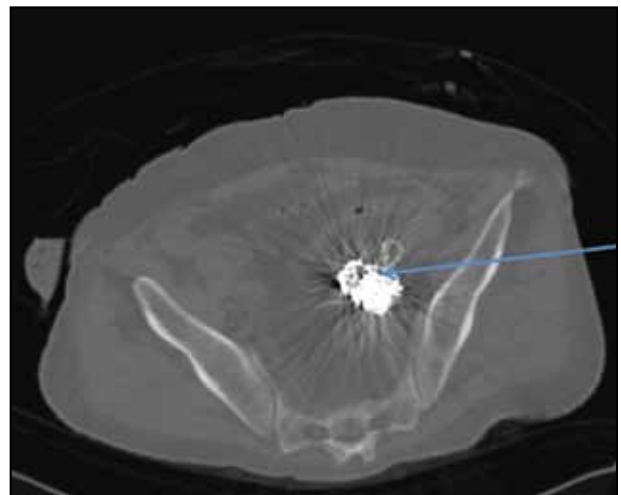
CT imaging after repair.
